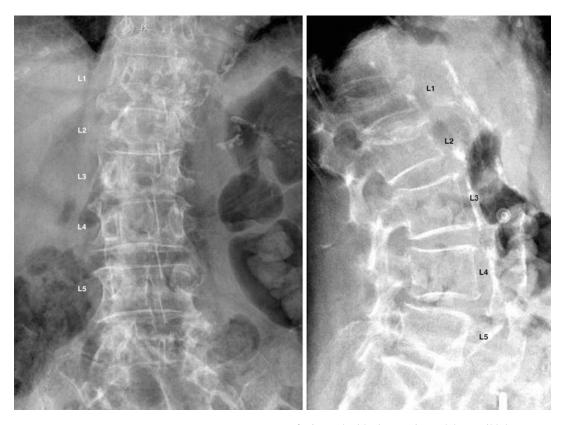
Lumbar spine X-ray. Description: Moderate compression deformity of L1 vertebral body superior endplate and age-indeterminate mild compression deformity
